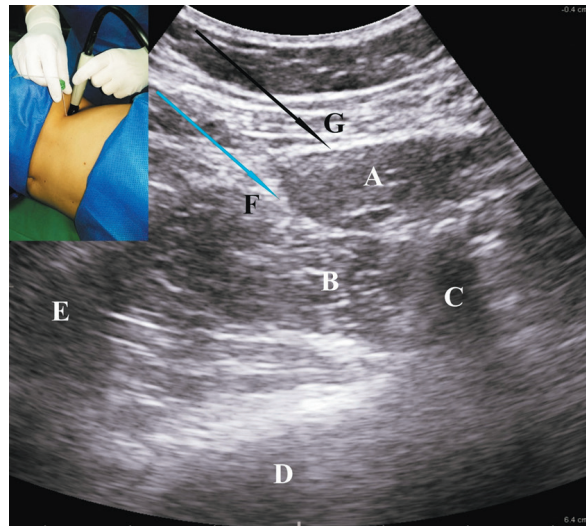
Ultrasound-guided Quadratus Lumborum Block Type I & II (QLB I & QLB II)
